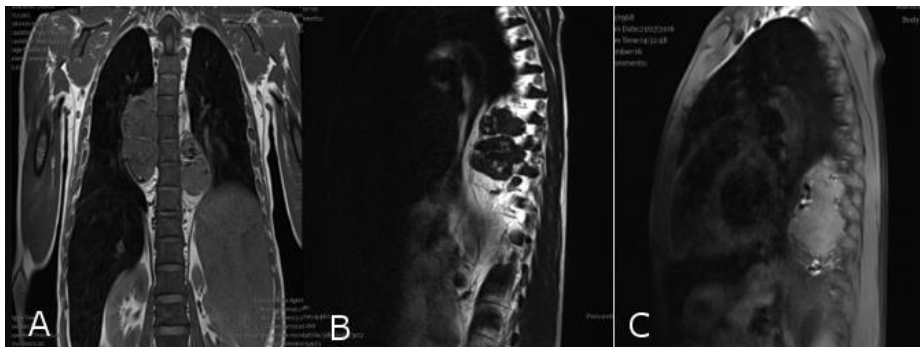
Figure a et b et c: Thoracic MRI: Coronal T1: Bilateral para-vertebral masses in heterogeneous T1 hypointense with T1 hyperintensity component. b: T2 sagittal: Fat component in T2 hyperignal. c: T1 FAT SAT sequence: Bilateral para-vertebral masses with fatty component which fades in FAT SAT sequence.
